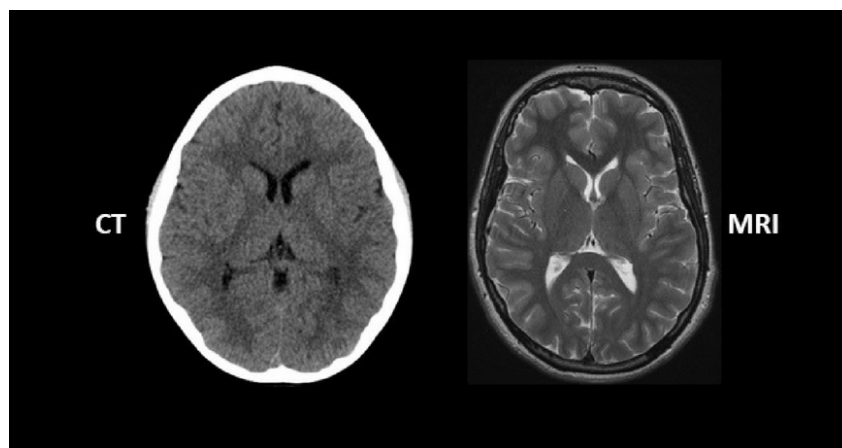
MRI VS CT scan of the brain [9]
